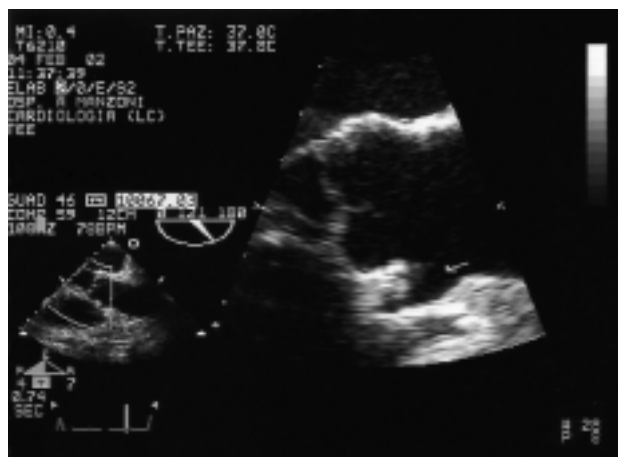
Transesophageal long-axis view of the aortic root.
